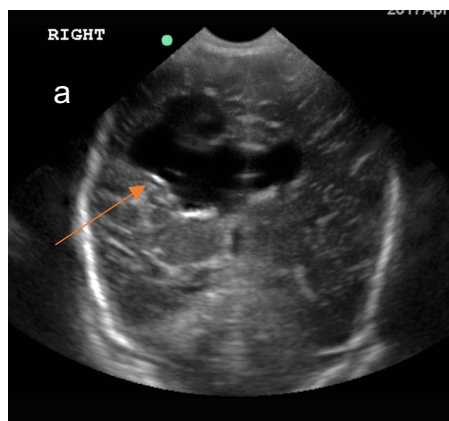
Example of a porencephalic cyst: a coronal ultrasound image of a large right parietal porencephalic cyst (arrow) extending from the lateral ventricle following a grade IV intraventricular haemorrhage in a preterm infant (Credit: K Burgoine)
